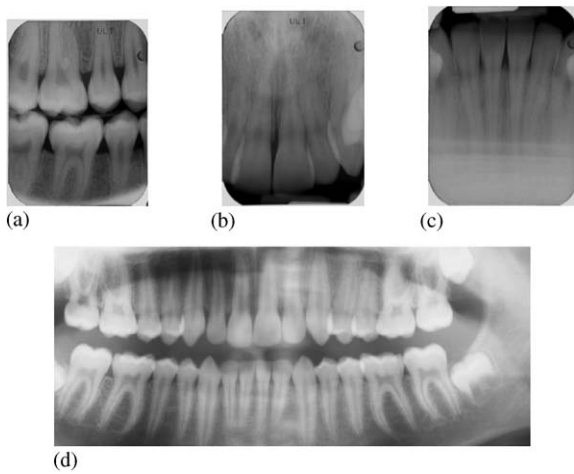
The three types of dental images: (a) bitewing; (b) upper periapical; (c) lower periapical; (d) panoramic.
